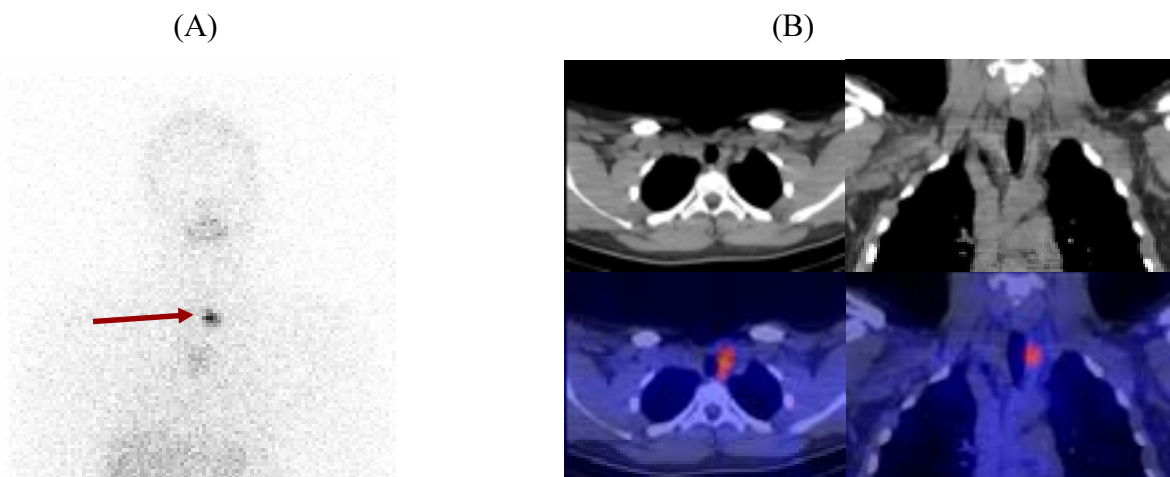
(A) The planar ^{131}I -iodide scan in a 16 year old patient with thyroid cancer discloses an iodine-avid focus (arrow). The patient had had three surgical procedures (including total thyroidectomy) and 37 GBq of ^{131}I , so that this focus indicates the presence of a further lymph node metastasis. Considering scarring from prior surgeries, exact localization of this lesion is an essential requisite for its surgical resection. This anatomic information can only be achieved by SPECT/CT (B).
